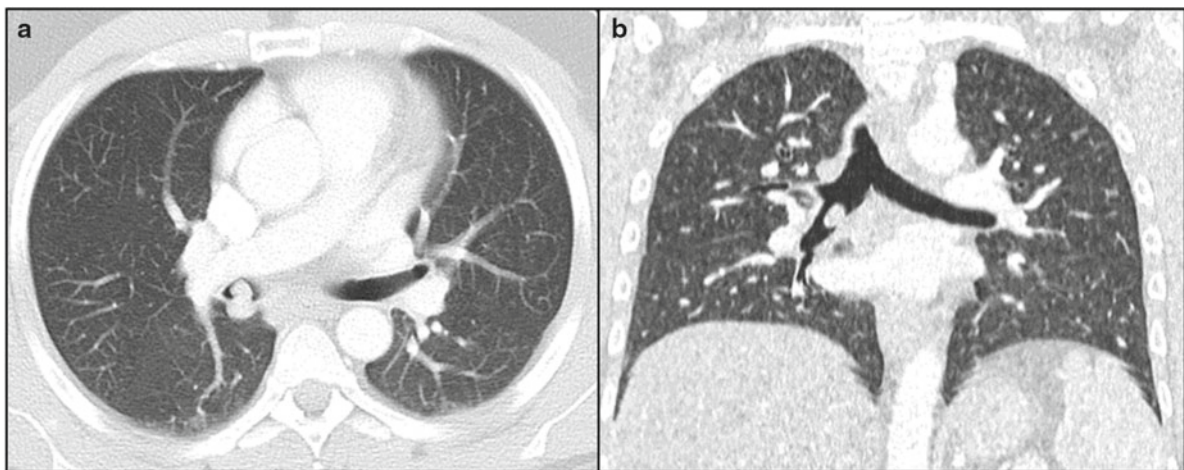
(a) transversal CT, (b) coronal reformat. The 37-year-old male patient presented with hemoptysis. CT revealed polypoid mass in the bronchus intermedius (a+b), which was identified as typical
